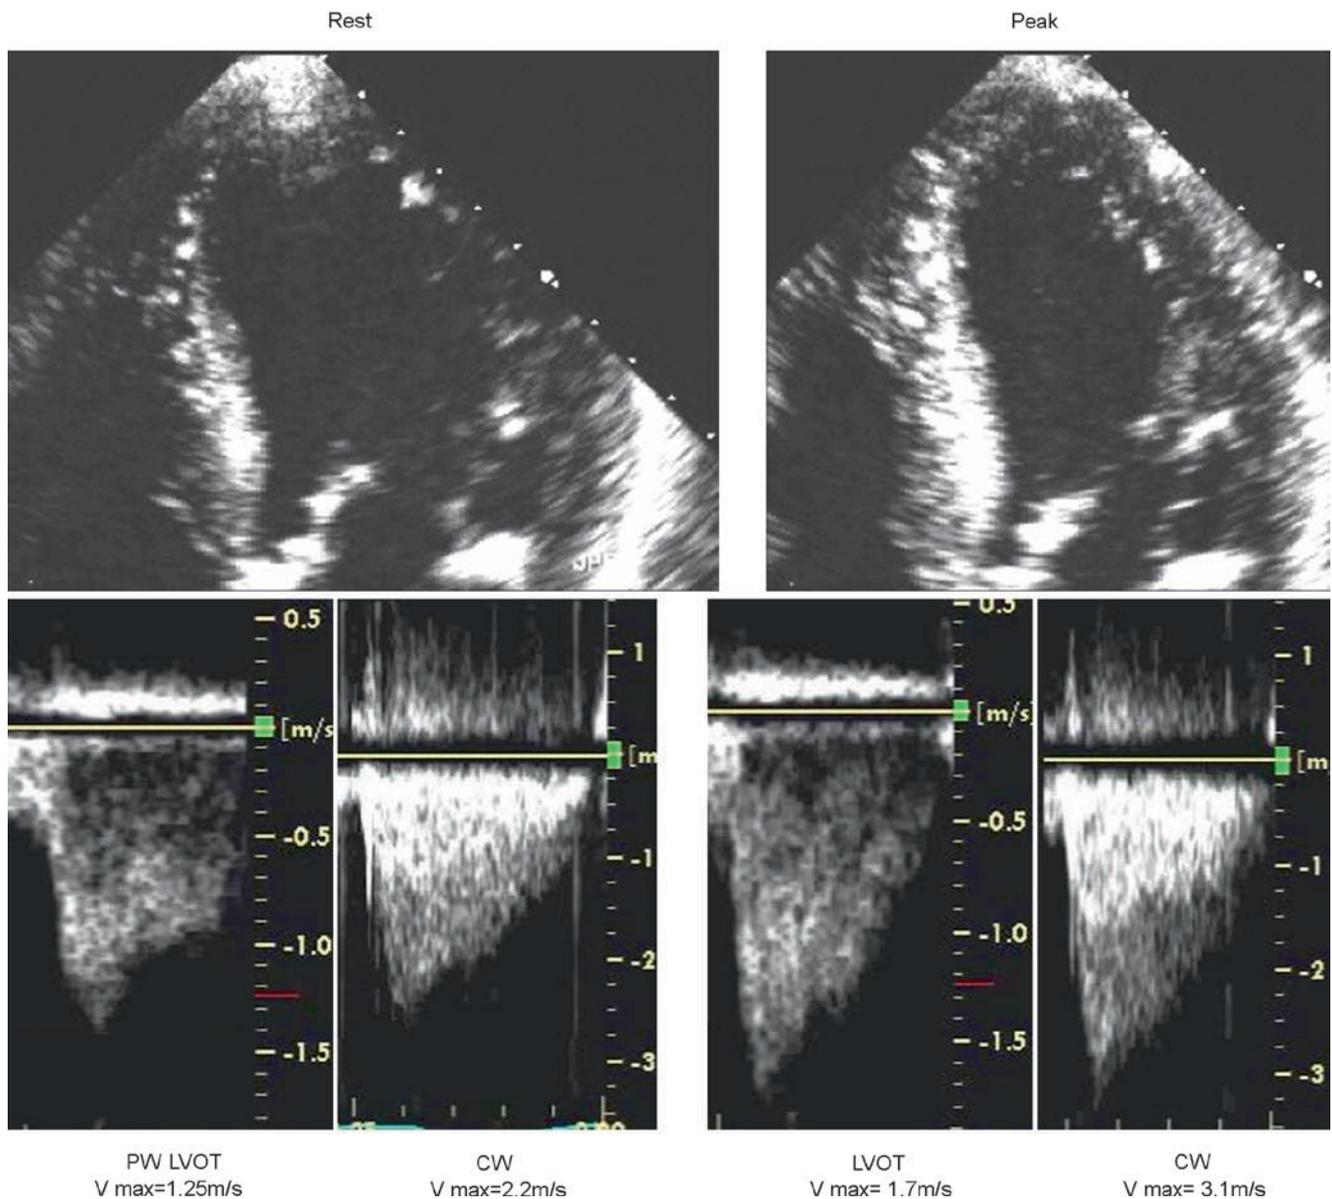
Exercise echocardiography in a patient with aortic prosthetic valve
